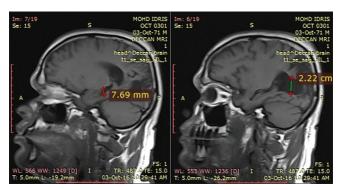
Magnetic resonance imaging of 45 yr old male showing temporal and occipital horn vertical diameter
